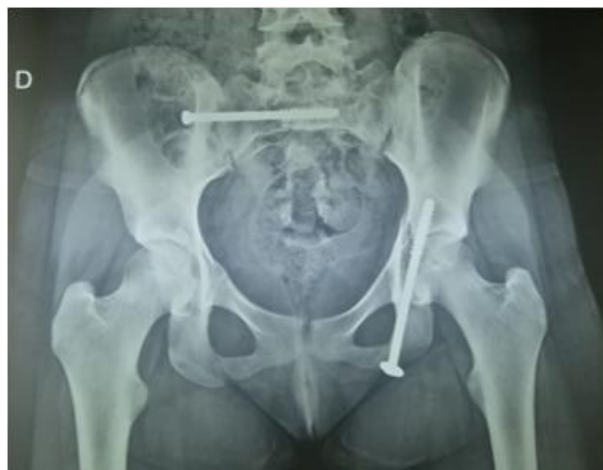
45 days post operative X-ray of the pelvis
